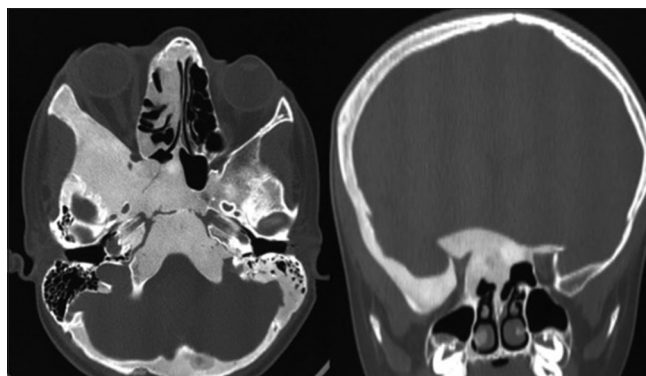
Computed tomography scan shows fibrous dysplasia of the skull base and orbit with narrowing of the optic canal
